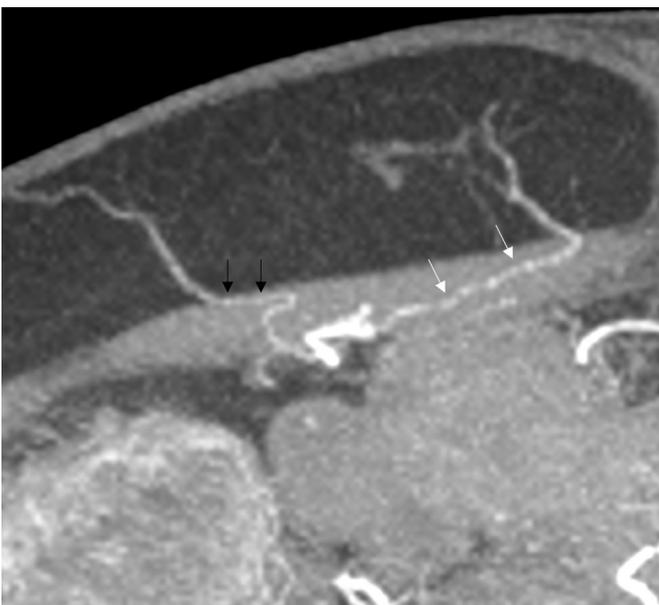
Axial 5 mm MIP reconstruction from CTA demonstrating two right-sided DIEPs. The more medial perforator has a relatively long intramuscular course (white arrows) measuring >3 cm, but no significant subfascial course. The more lateral perforator demonstrates a short intramuscular course and 15 mm subfascial course (black arrows).
